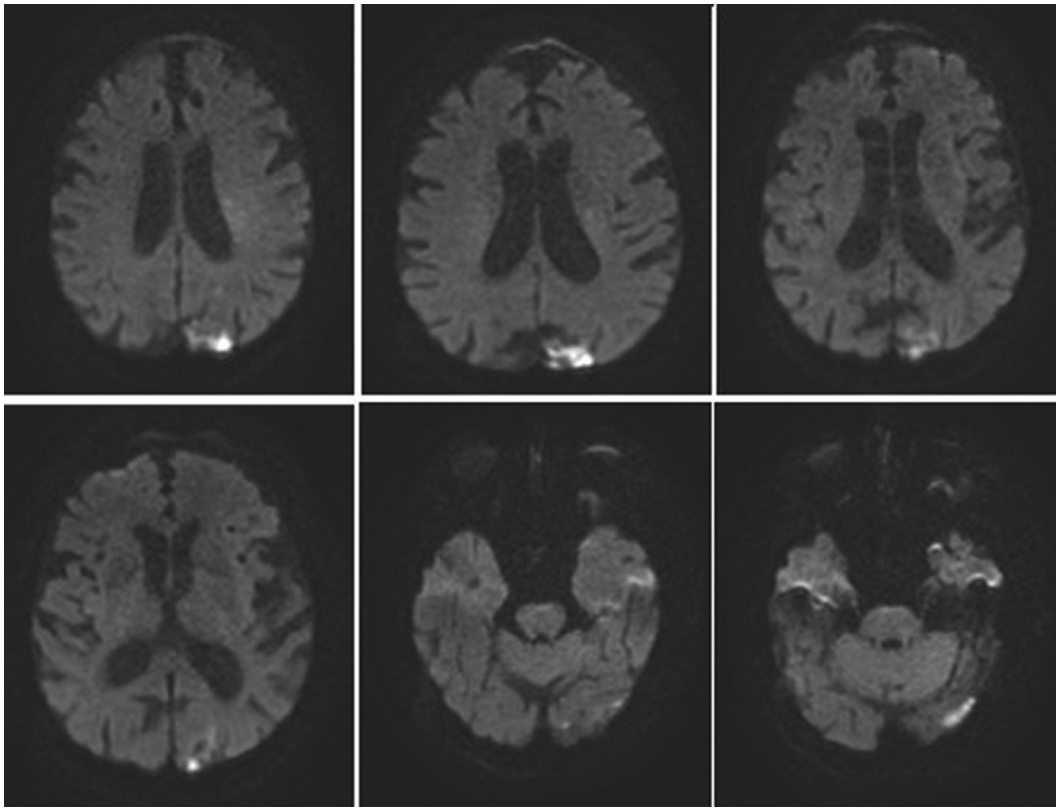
Diffusion-weighted MRI brain.
